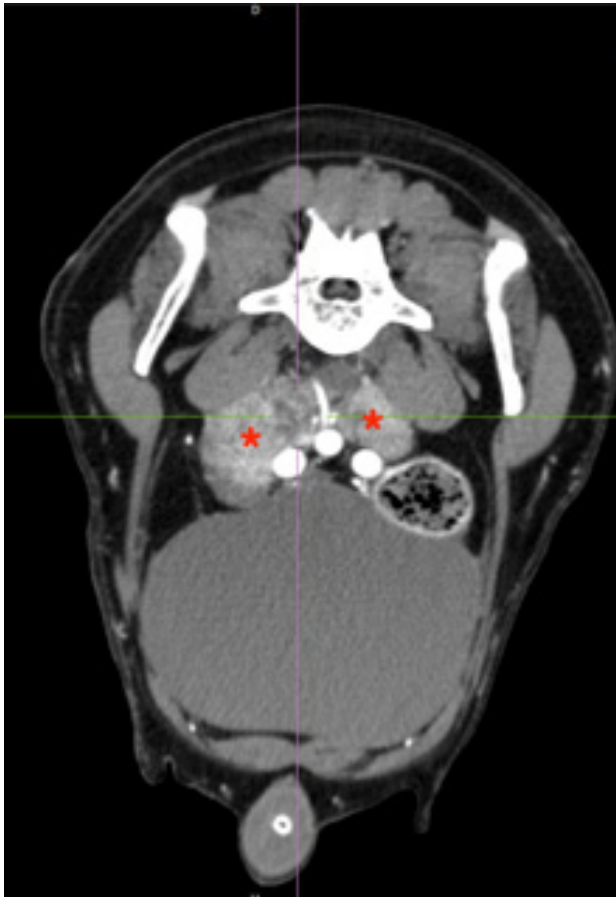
Transverse computed tomography projection showing a heterogeneous contrast-enhancing markedly enlarged metastatic sub-lumbar lymph node (red star)
